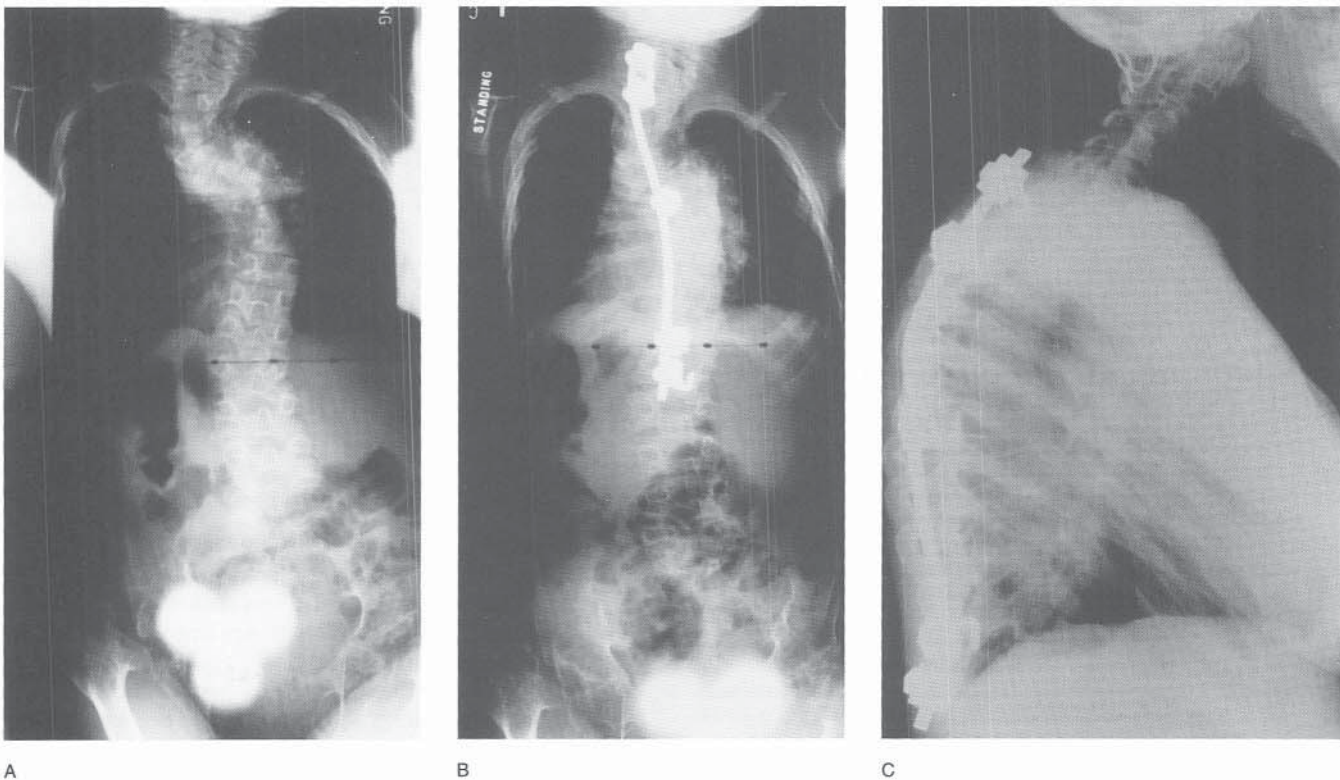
A to C, Radiographs of a 9-year-old child with scoliosis secondary to diastrophic dysplasia. Spinal fusion was performed using TSRH instrumentation.
